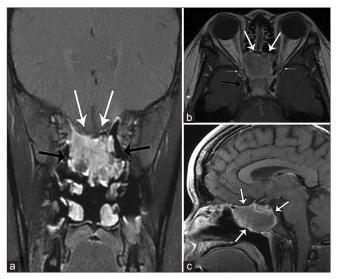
Four month post treatment coronal (a), axial (b), and sagittal (c) postcontrast TI MR images, demonstrate decreased size of the lymphoma mass in the nasal cavity, along the cribriform plates, and prepontine cistern
